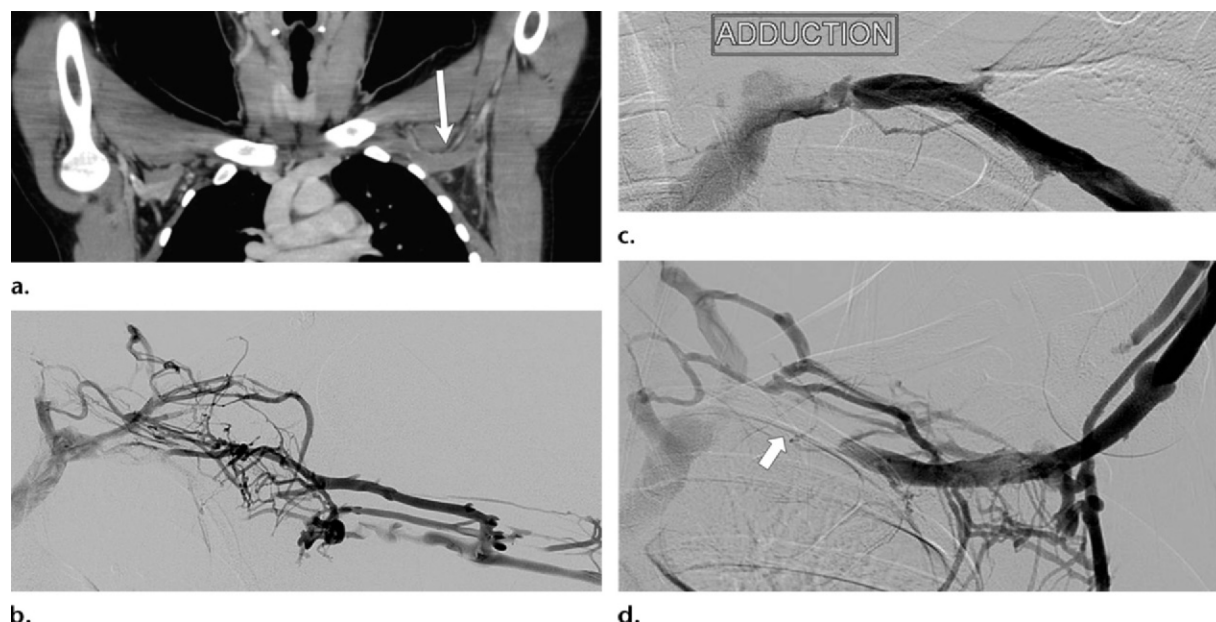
TOS due to venous compression (Paget-Schroetter syndrome) in a 16-year-old swimmer with a 1-week history of swelling and cyanosis in the left arm. (a) CT angiogram demonstrates left subclavian and axillary vein thrombosis (arrow). (b) Venogram obtained at DSA with the arm abducted 90° shows left axillary and subclavian vein thrombosis with multiple venous collaterals. (c) Venogram obtained at DSA with the arm adducted, 24 hours after venous catheterization and thrombolysis, shows a patent irregular subclavian vein with an abrupt severe stenosis in the costoclavicular space. (d) Venogram obtained at DSA after thrombolytic therapy shows subclavian vein occlusion (arrow), a typical feature of TOS, when the arm is hyperabducted.
